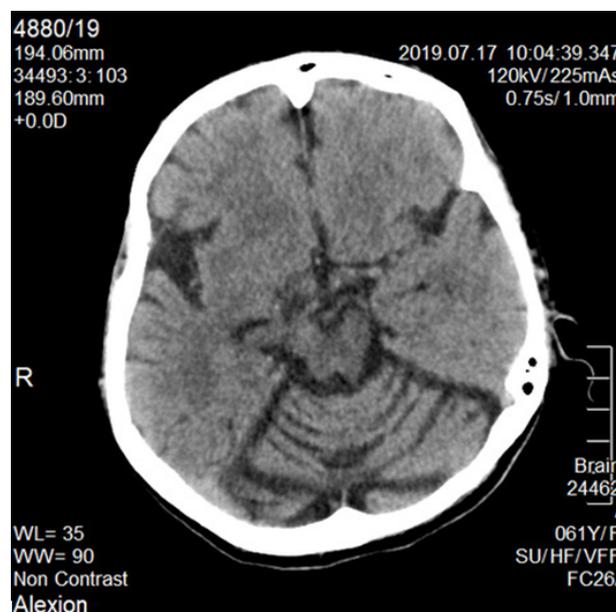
Non-contrast CT scan of the brain showing selective cerebellar atrophy.
